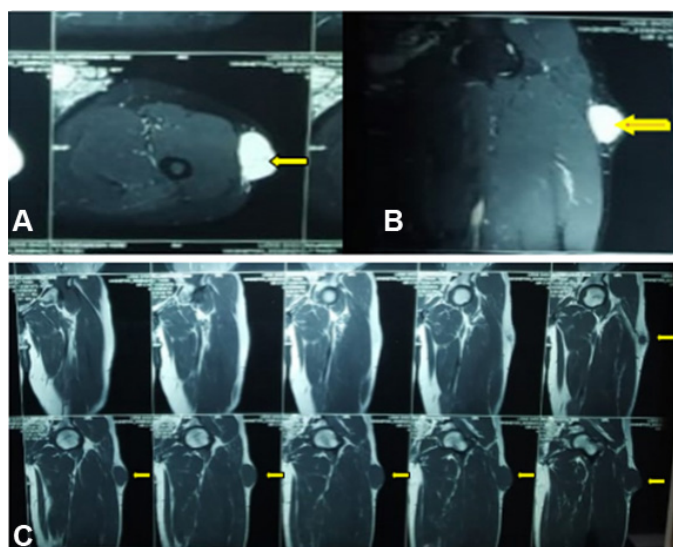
(A)–(C) Magnetic resonance imaging showing about $6 \times 5.8 \times 3.5$ cm lesion with no intermuscular plane seen in coronal and sagittal plane shows perilesional fat plane (arrow).
